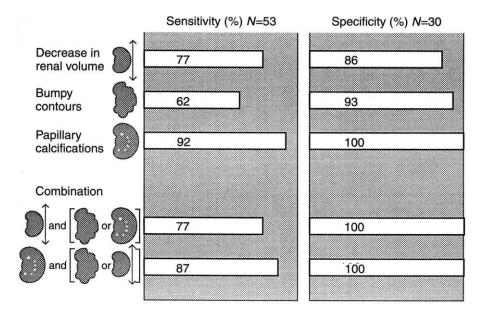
Performance of the renal imaging criteria using CT scan in patients with incipient-moderate renal failure ($S_{Cr}=1.5$ to 4 mg/dl or 170 to 450 mmol/liter). Combination 1 can be defined as a decreased renal volume combined with either bumpy contours or papillary calcifications. Combination 2 can be defined as papillary calcifications combined with either bumpy contours or decreased renal volume.
